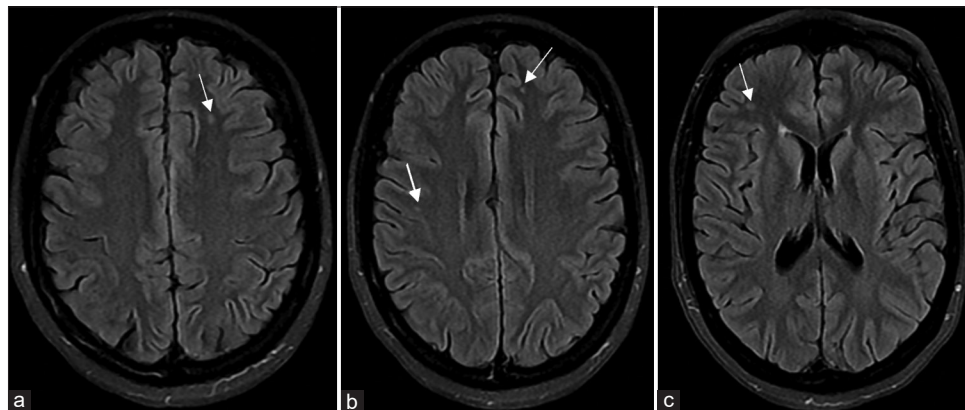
Axial sections of plain MRI brain fluid-attenuated inversion recovery (FLAIR) sequences showing the tiny focus of hyperintensity in left centrum semiovale (a), left anterior frontal lobe and right parietal lobe (b), and right frontal lobe (c)
